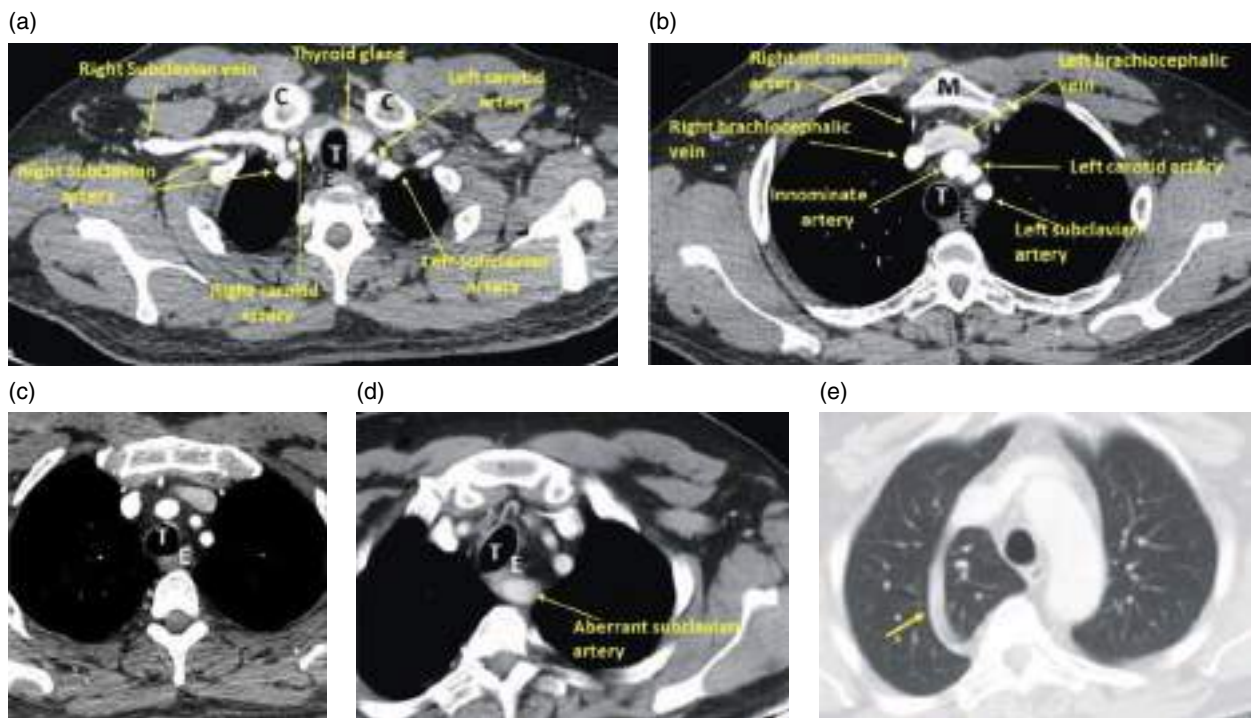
Supra-aortic mediastinum. (a–d) Axial contrast-enhanced CT image (mediastinal window). C, clavicle; T, trachea; M, sternal manubrium; E, esophagus. (e) Axial contrast-enhanced CT image (lung window). Arch of the azygos with posterior azygos vein lying more lateral to its normal course (arrow).
